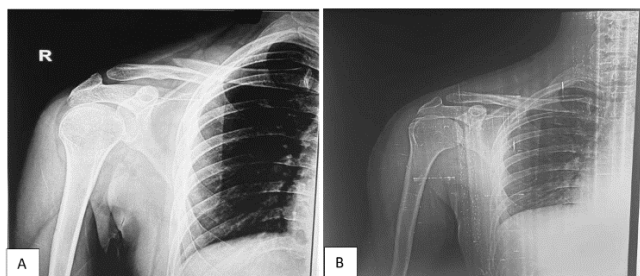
A): X-ray at injury; B): Follow up at 12 months
